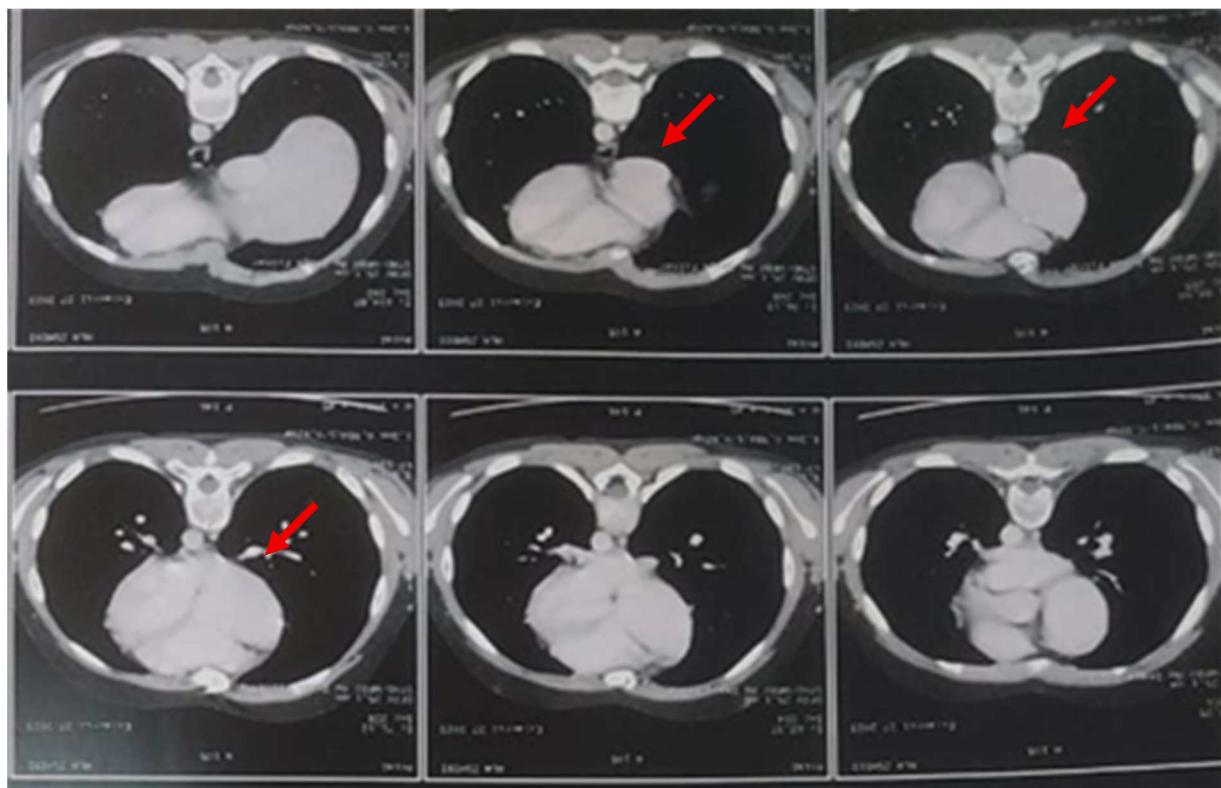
Thoracic CT scan showing a highly enhanced tissue mass arising from the right ventricle of the heart.
